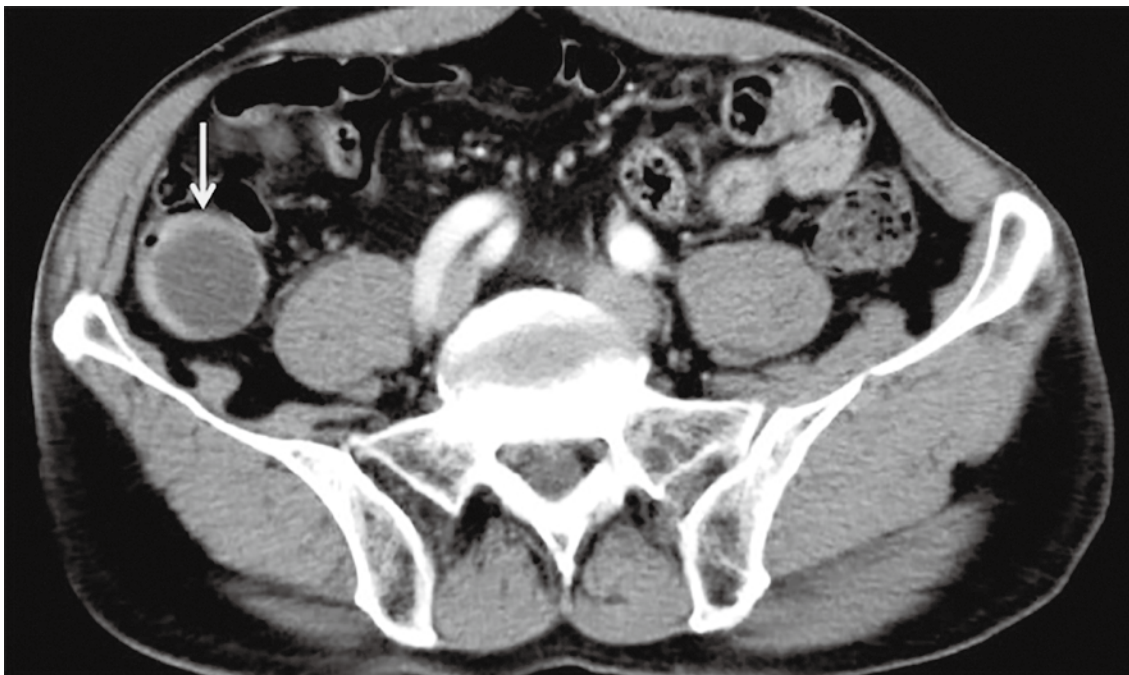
Computed tomography
